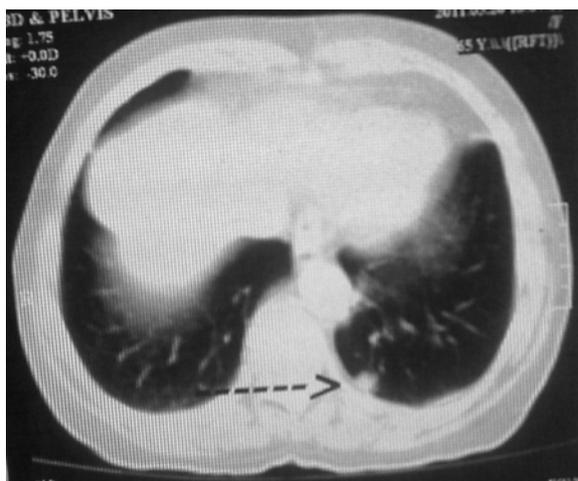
Chest CT showing small metastasis in left lung base (same patient as in Fig. 6).
